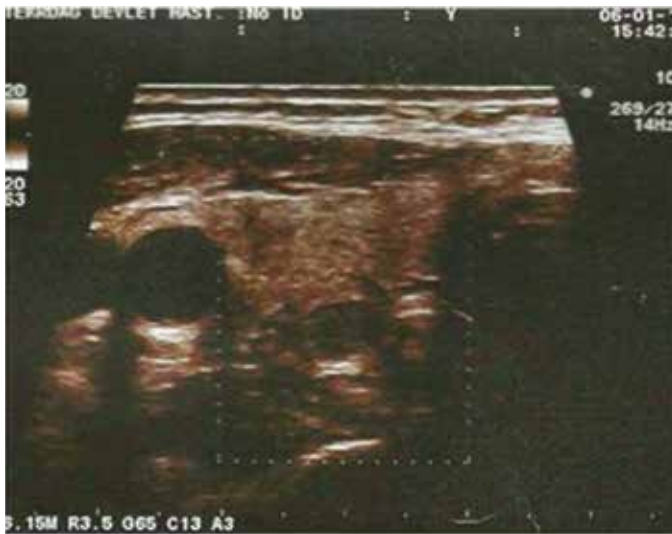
Neck ultrasound shows homogenous hypoechoic solid mass lesion in the inferior of right lobe of thyroid
